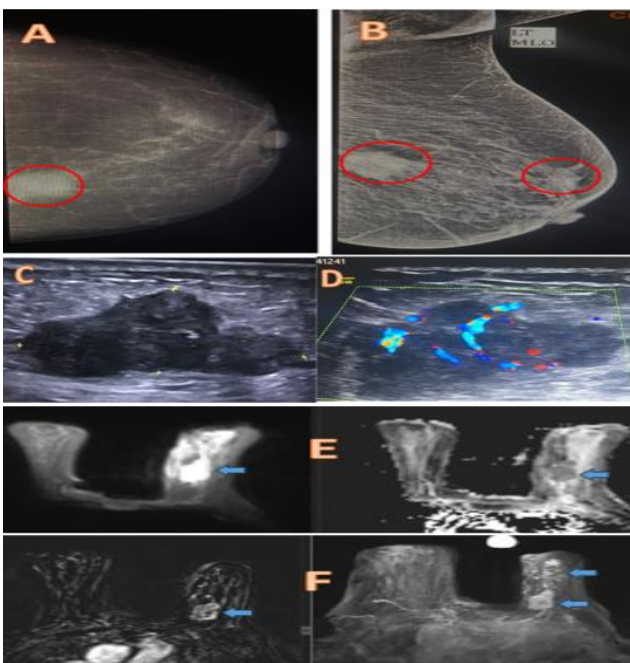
((A) Left mammography CC & (B)left MLO showing dense breast (ACR b) with left UIQ irregular indistinct high-density masses (red circles). (C) US showed irregular indistinct hypoechoic mass, (D)Color Doppler examination of the mass revealed internal vascularity(E) DWI show mass of restricted diffusion reaching nipple areola complex (high in DWI, low ADC), (F)MRI-DCE show Left breast UIQ irregular heterogeneously enhancing lesion with non-mass enhancement is seen from the dominant mass reaching nipple areola complex. (blue arrow).
